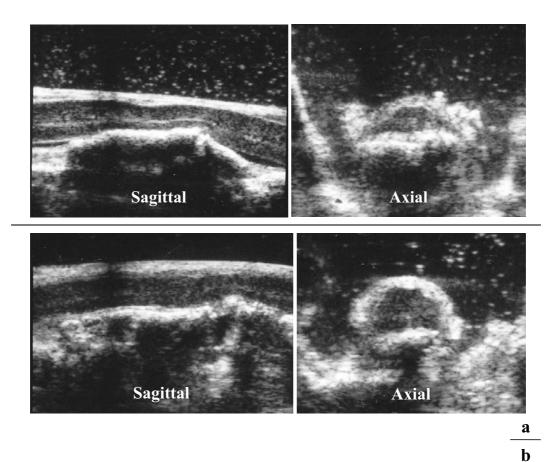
Intraoperative ultrasonographic findings. a: Anterior spinal cord compression evaluated by sagittal and axial ultrasonography before the removal of OPLL. b: Spinal cord evaluated via sagittal and axial ultrasonography after the removal of OPLL.
